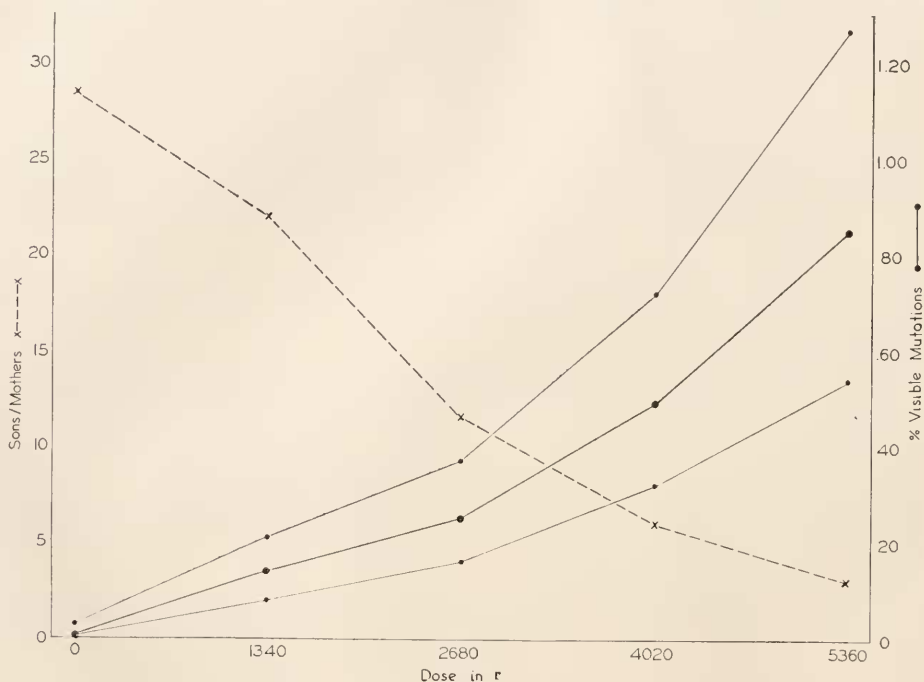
Average numbers of sons per mother and percentages of eye-color mutations produced by *Mormoniella* females, control and x-rayed with different doses. Lower and upper 0.95 confidence limits calculated from Ricker's (1937) table are given for the mutation percentages.
